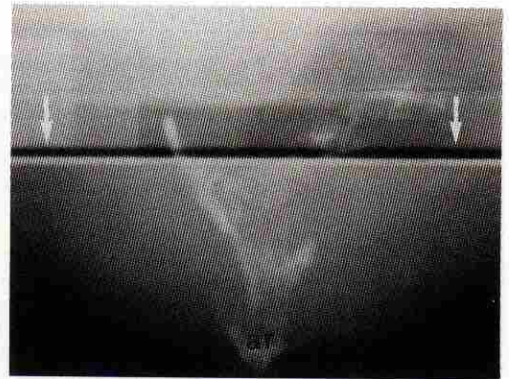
Spot radiograph obtained after evacuation shows severe intra-anal intussusception (intra-anal rectal prolapse) in the same patient as in Figure 5a. The edge of the radiolucent commode (*arrows*) can be seen. (ar = anorectal junction)
